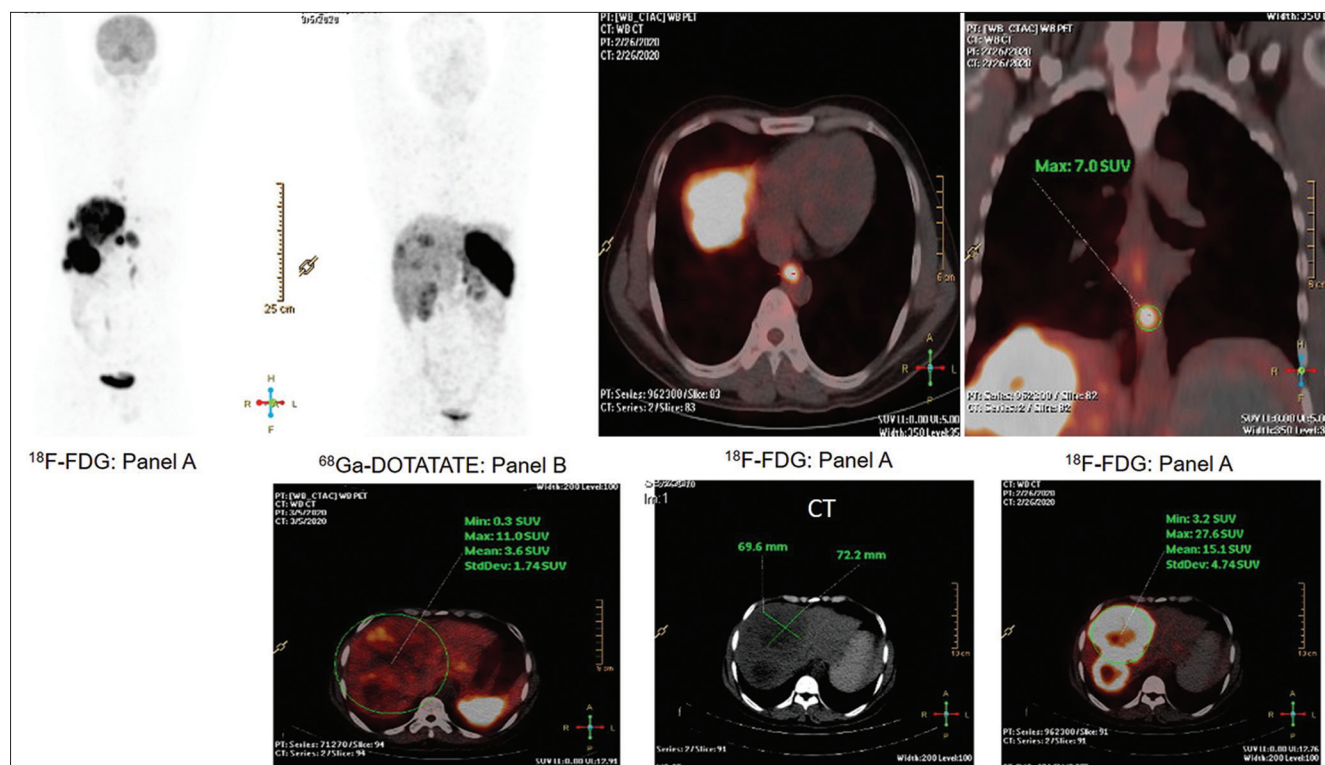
Dual tracer positron emission tomography and computed tomography evaluation (¹⁸F-fluorodeoxyglucose and ⁶⁸Ga-DOTATATE) demonstrates the progression of disease with fluorodeoxyglucose avid lesions of the lower third part of the esophagus (now measuring approximately 4.5 cm), multiple hypodense liver lesions (largest measuring 7.2 cm × 7 cm), multiple abdominal enlarged lymph nodes (largest perigastric lymph node measuring 4.1 cm × 2.9 cm) all showing more avidity on 18F fluorodeoxyglucose scan (panel A) compared to ⁶⁸Ga-DOTATATE positron emission tomography and computed tomography (panel B)
